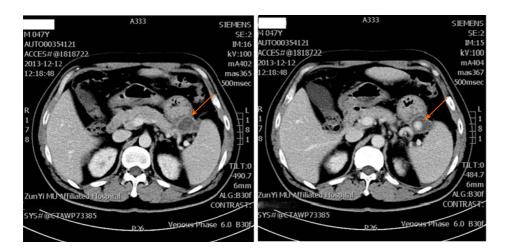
Computed tomography images confirmed that the pancreatic pseudocyst invaded part of the spleen and greater curvature of the stomach.
